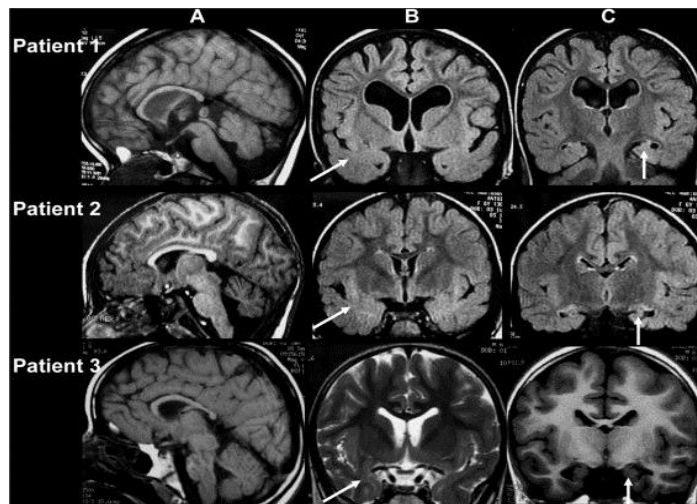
Radiographic image of a brain with Pitt-Hopkins
